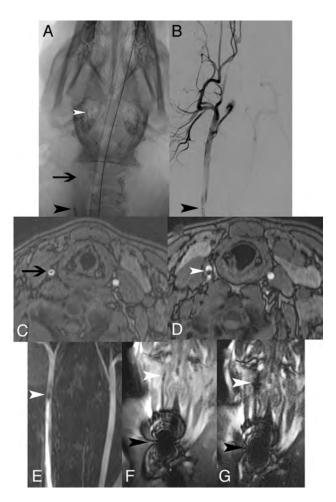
In vivo x-ray, DSA, axial MRA, coronal MRA MIP, and coronal SSFP. Unsubtracted x-ray image (A) demonstrates MARC catheter tip coils (*white arrowhead*), microcatheter shaft with lead wires (*black arrow*), and guiding catheter (*black arrowhead*) in the right CCA. Only the guiding catheter tip marker is readily evident on the equivalent DSA image (B). Susceptibility from the catheter shaft lead wires (*black arrow*) and catheter tip (*white arrowhead*) is seen on axial MRA (*C and D*), coronal MRA MIP (*E*), and coronal SSFP (*F*). With a 300-mA current applied (*G*), the catheter tip coils are more apparent (*white arrowhead*). Guide catheter tip artifacts resulting from a metallic marker band are very prominent on the SSFP sequence (*F* and *G*).
